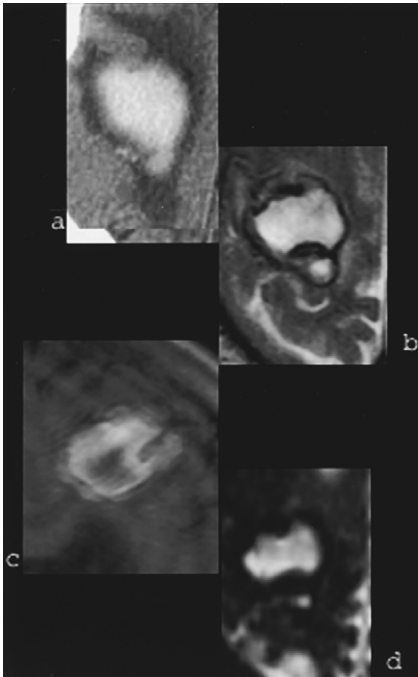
Hypertensive lobar hemorrhage. (a) Acute hematoma in the right frontal lobe. High signal on the T1-weighted image (T1WI) and T2-weighted image (T2WI) obtained 10 days later indicates extracellular methemoglobin. A hemosiderin rim has already formed (b) and is better seen on the diffusion-weighted image (c). Note that hyperacute and late subacute hemorrhage may be identical on the T2WI, emphasizing the importance of evaluating both the T1WI and T2WI together (compare with Fig. 1).
